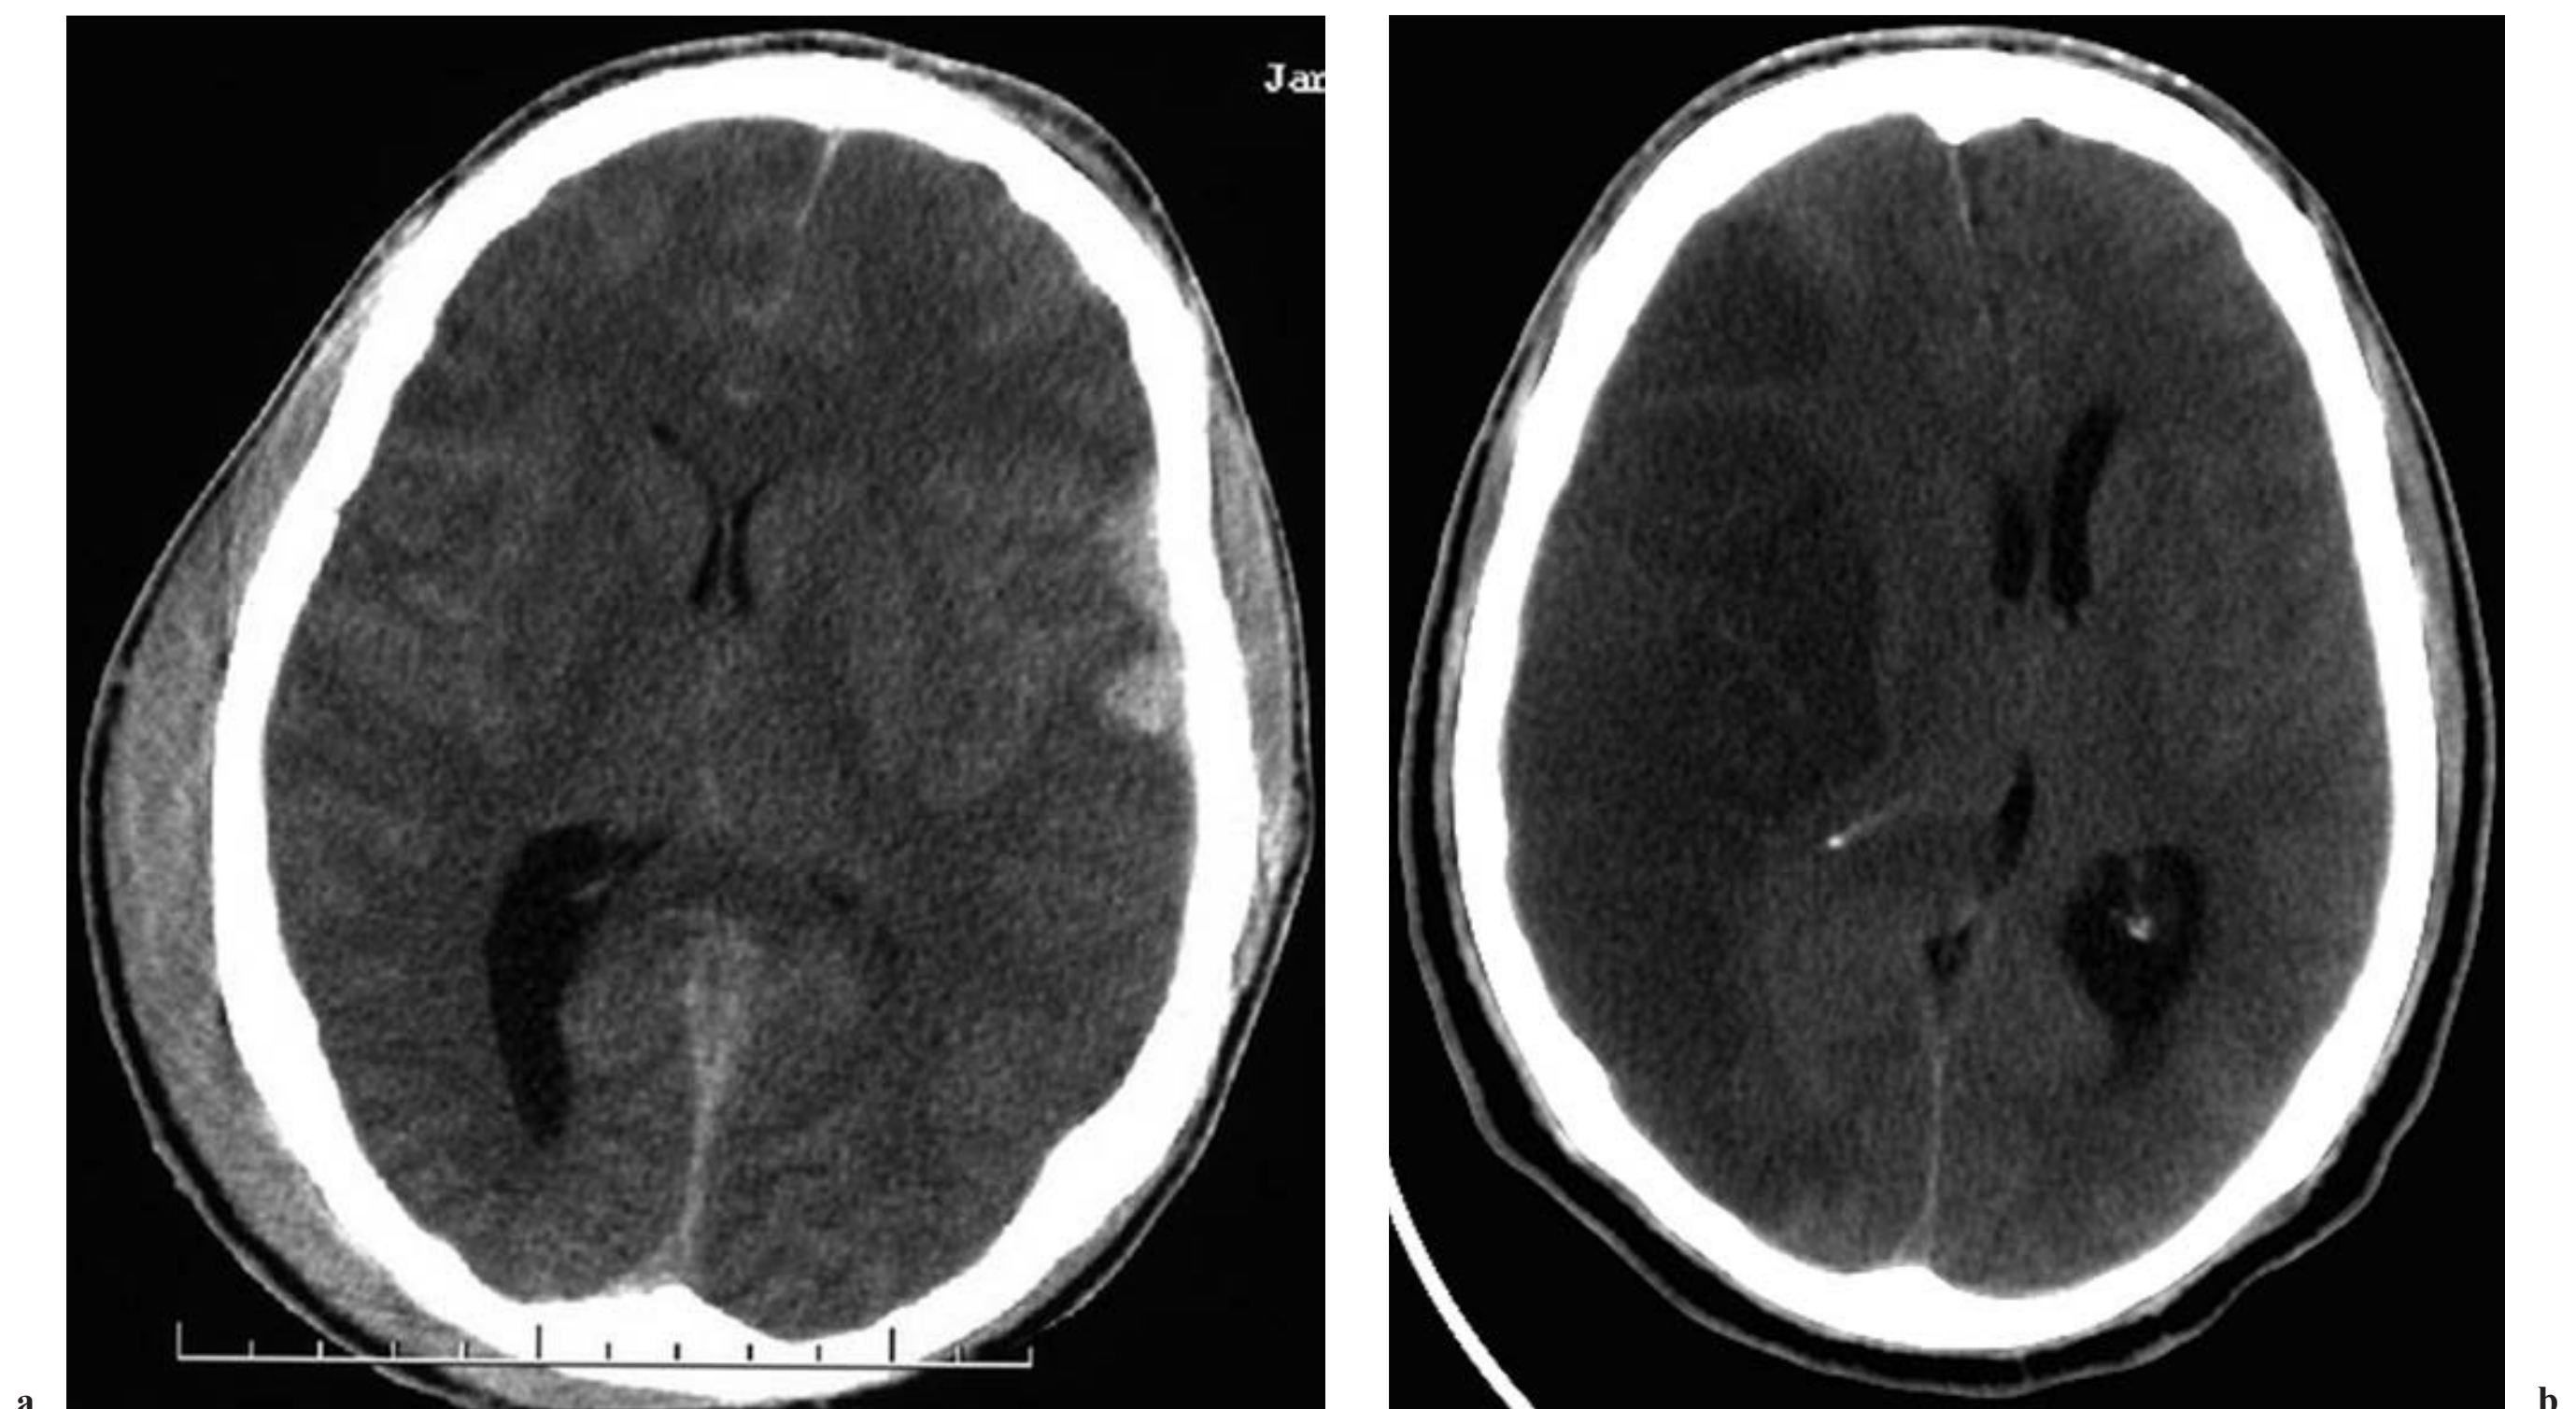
Axial CT images for two patients—(a) one with traumatic brain injury and (b) one with a large right MCA stroke—selected for decompressive craniectomy.
